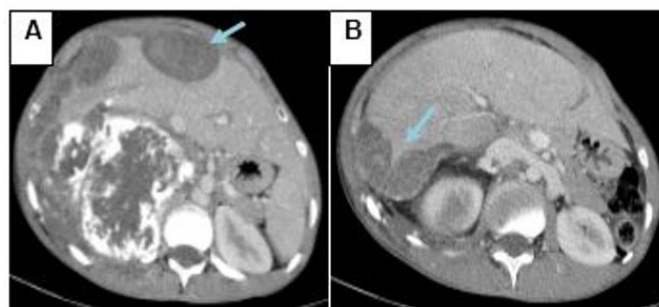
Abdominal CT scan with contrast injection: axial sections (A, B) showing hypodense, oval peritoneal nodules containing calcifications, scalloping on the liver.
